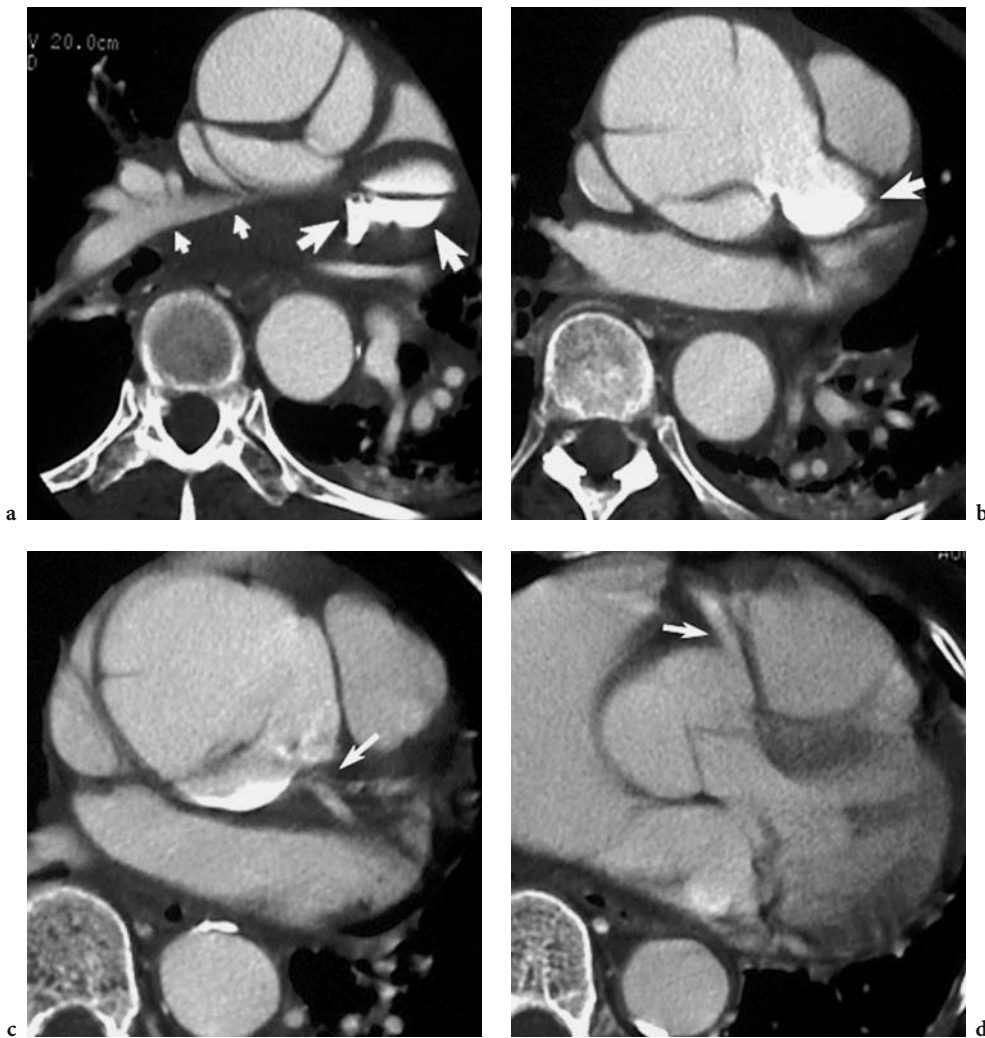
a, b Transverse CT sections in a patient with acute chest pain demonstrates a type-A aortic dissection with posteromedial rupture of the proximal ascending aorta and active extravasation of arterial contrast medium into the mediastinum through a pseudoaneurysm (*large arrows*). A mediastinal hematoma is resulting in substantial right pulmonary arterial compression (*small arrows*). c The original left main coronary artery could be visualized one section below this image, which demonstrates the proximal left, centered, and circumflex coronary arteries (*arrow*) originated immediately below the pseudoaneurysm from the left sinus of Valsalva. d The right coronary artery origin is clearly uninvolved (*arrow*), as is the aortic valve
